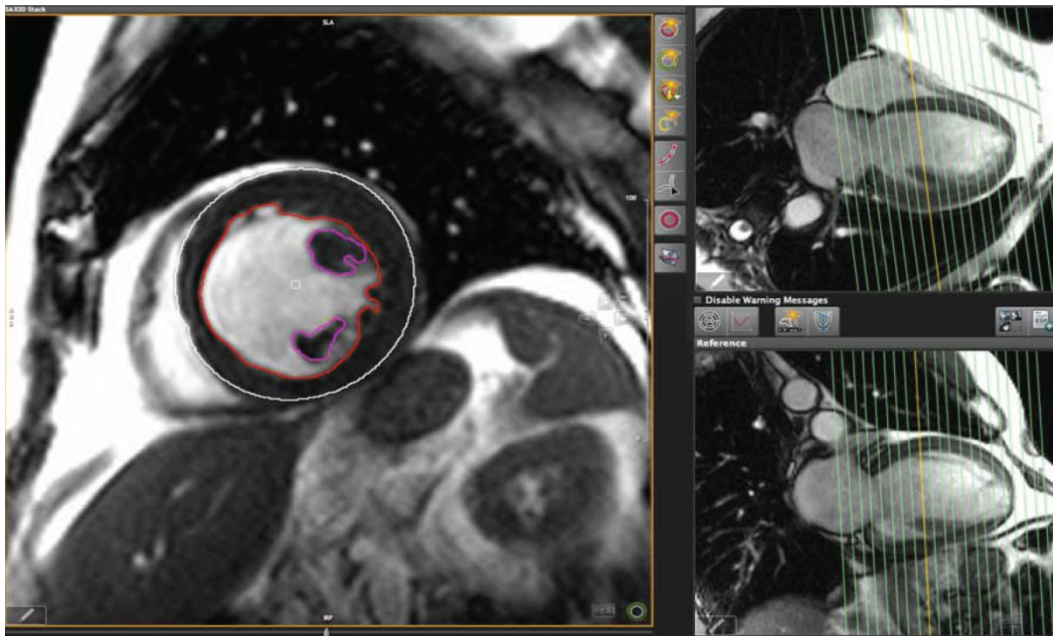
Cardiovascular MRI. Short axis analysis (left) using long axis views as a cross-reference (right). [Adapted from Childs et al. (2011)].
